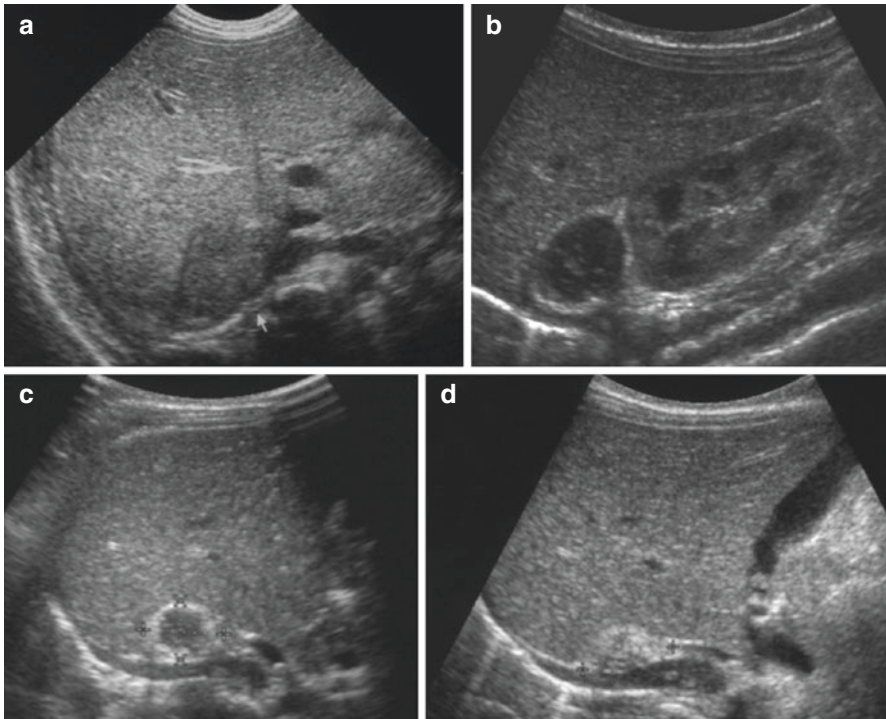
A 5-day-old newborn with adrenal haemorrhage. At 5 days of age, ultrasonography showed a solid mass in the right suprarenal region (a). After 40 days, the same mass appeared more hypoechoic and surrounded by a hyperechoic shell; vascularization of the mass was not seen with colour Doppler (b). After further 2 months, the suprarenal mass was smaller, whereas the echo-structure appeared unchanged (c). At 6 months of age, ultrasonography showed a very small, calcific mass (d)
